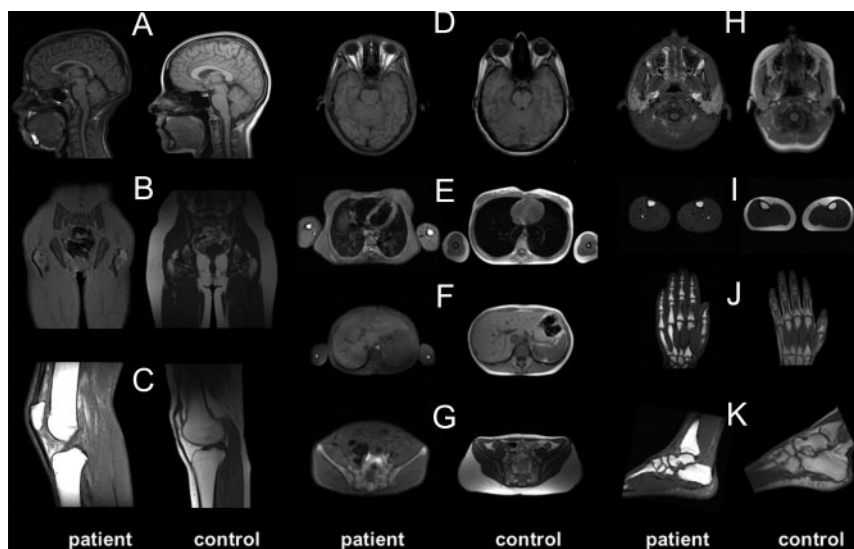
MR images in the proband and an age-, sex-, and ethnically matched control subject. T1 weighted images from the proband are presented on the *left* and those from the control subject on the *right*: axial images of brain (D), neck (H), chest and arms (E), abdomen (F), pelvis (G), and legs (E–I); sagittal images of brain and upper neck (A) and knees (C) and coronal images of hips (B), left hand (J), and left foot (K). Subcutaneous fat is absent in the limbs and trunk, with only trace amounts in the posterior neck and back regions (A–C, E–G, and I). In the head, it is near absent in the scalp, reduced in the temples, but preserved in the retroorbital region (A, D, and H). In the extremities, adipose tissue is preserved in fingers (J) and plantar region (K), although it displays loss of brightness. Visceral fat is also negligible in the intrathoracic and intraabdominal regions (B and E–G). Bone marrow fat is preserved (C, J, and K). Muscular hypertrophy (C) is also evident.
